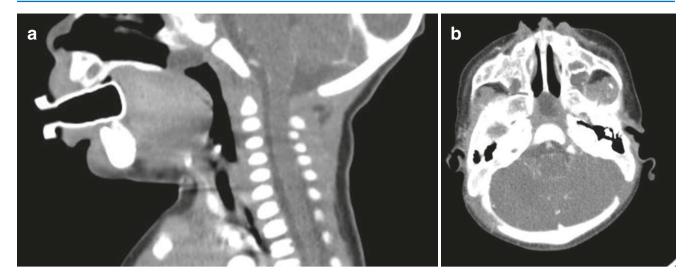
(a) Sagittal CT scan shows a nonenhancing mass in the posterior nasopharyngeal wall. (b) Axial CT scan shows a nonenhancing mass in the posterior nasopharyngeal wall
